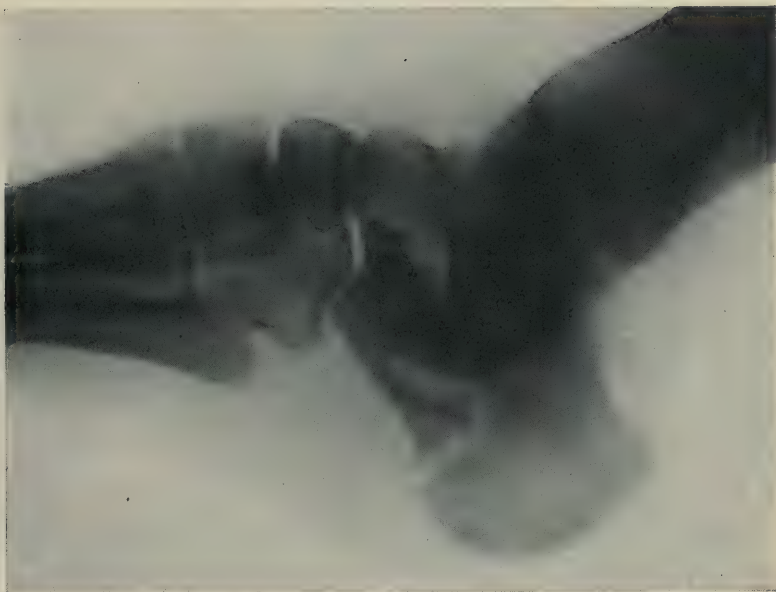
Fracture of the os calcis. Man, 26, fell from moving car, striking left foot against tie. In May, 1899, X-ray shows fracture of os calcis, large heel fragment type, with tendency of posterior fragment to be drawn upward. Plaster of Paris bandage.
